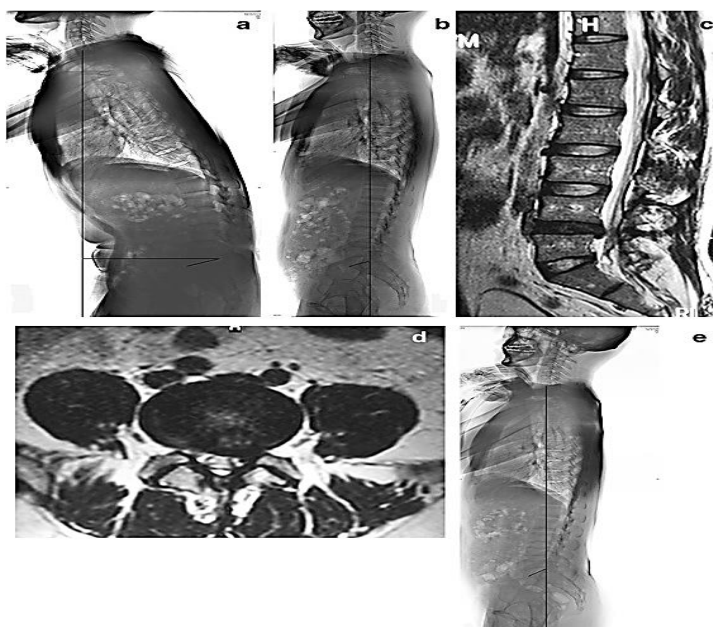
36-year-old body builder with disc herniation (L4/ 5) (patient no. 3). (a) represents a lateral radiograph before operation, showing the sagittal imbalance (SVA= 18.4 cm). (b) radiograph immediately after the operation, showing sagittal balance which is restored. (c) and (d) MRI showing disc herniation (L4/ 5) with impingement of nerve root (left L5). (e) radiograph after 2.5 years of operation, presenting sagittal balance (SVA= 0.6 cm)
